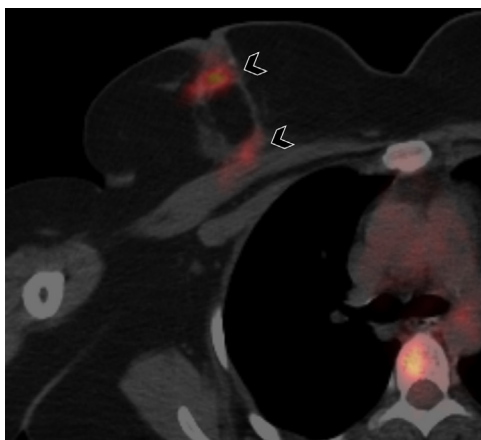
PET/CT demonstrating focal fluorodeoxyglucose (FDG) uptake in the right breast. Fused axial images from a PET/CT performed 2 years before the SPECT/CT (shown in Fig. 6). There is avid FDG uptake within the periphery of the fat necrosis in the right breast (arrowheads).
